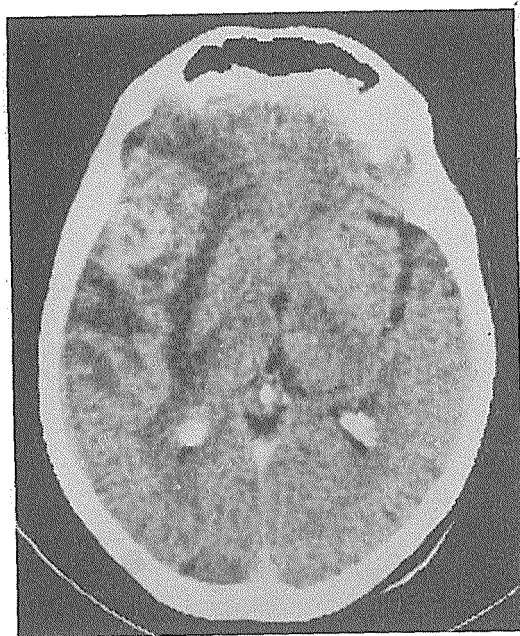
Brain CT in January 1991.
